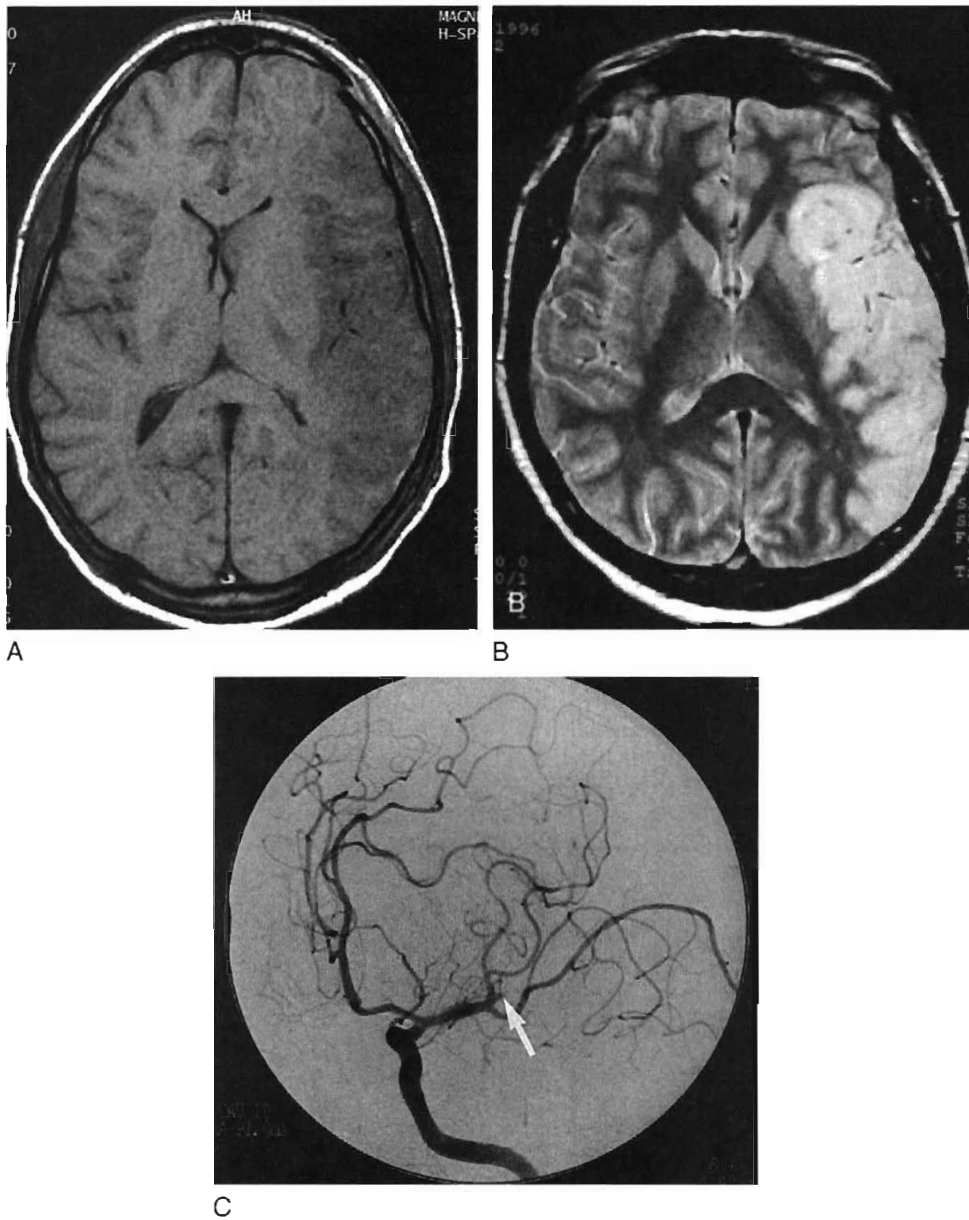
Infarct. Axial T1-weighted (A) and T2-weighted (B) MRI scans of a patient being evaluated for stroke. The initial CT scan (not shown) was normal. MRI demonstrates an area of cytotoxic edema involving the distal left middle cerebral artery territory. The edema is hypointense to brain on the T1-weighted image and hyperintense to brain on the T2-weighted image. Left internal carotid artery angiogram (C) demonstrates the occluded branch of the left middle cerebral artery (arrow). Within the proper time frame, intra-arterial thrombolysis would be a method of management for this patient.
